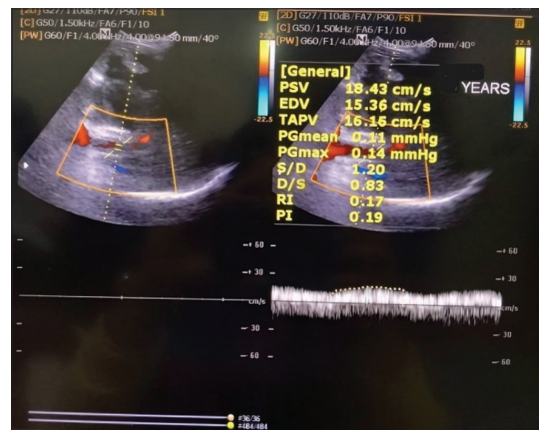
Doppler study of the portal vein in a liver cirrhosis patient with portal hypertension during our research
